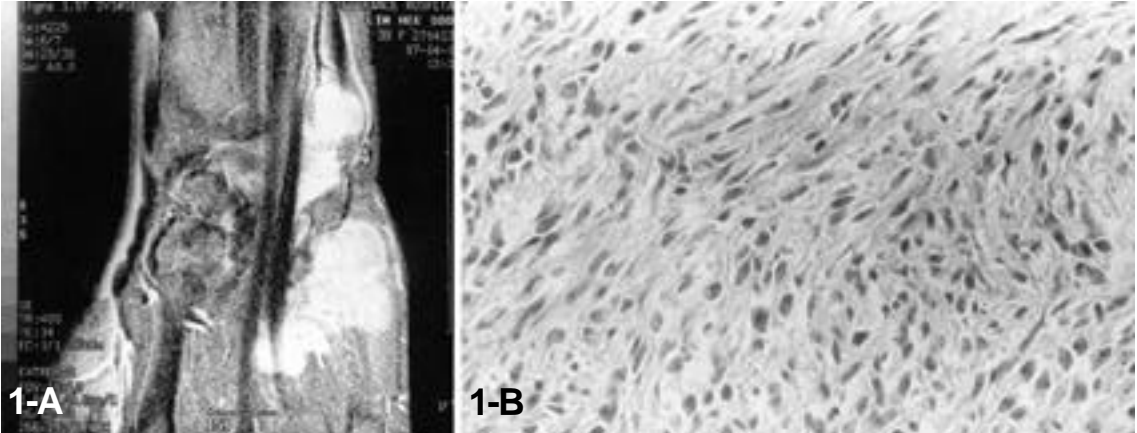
Enhanced coronal T1WI of the preoperative MRI shows a soft tissue mass with high signal intensity about the flexor carpi ulnaris tendon insertion site at distal ulna and palm.
